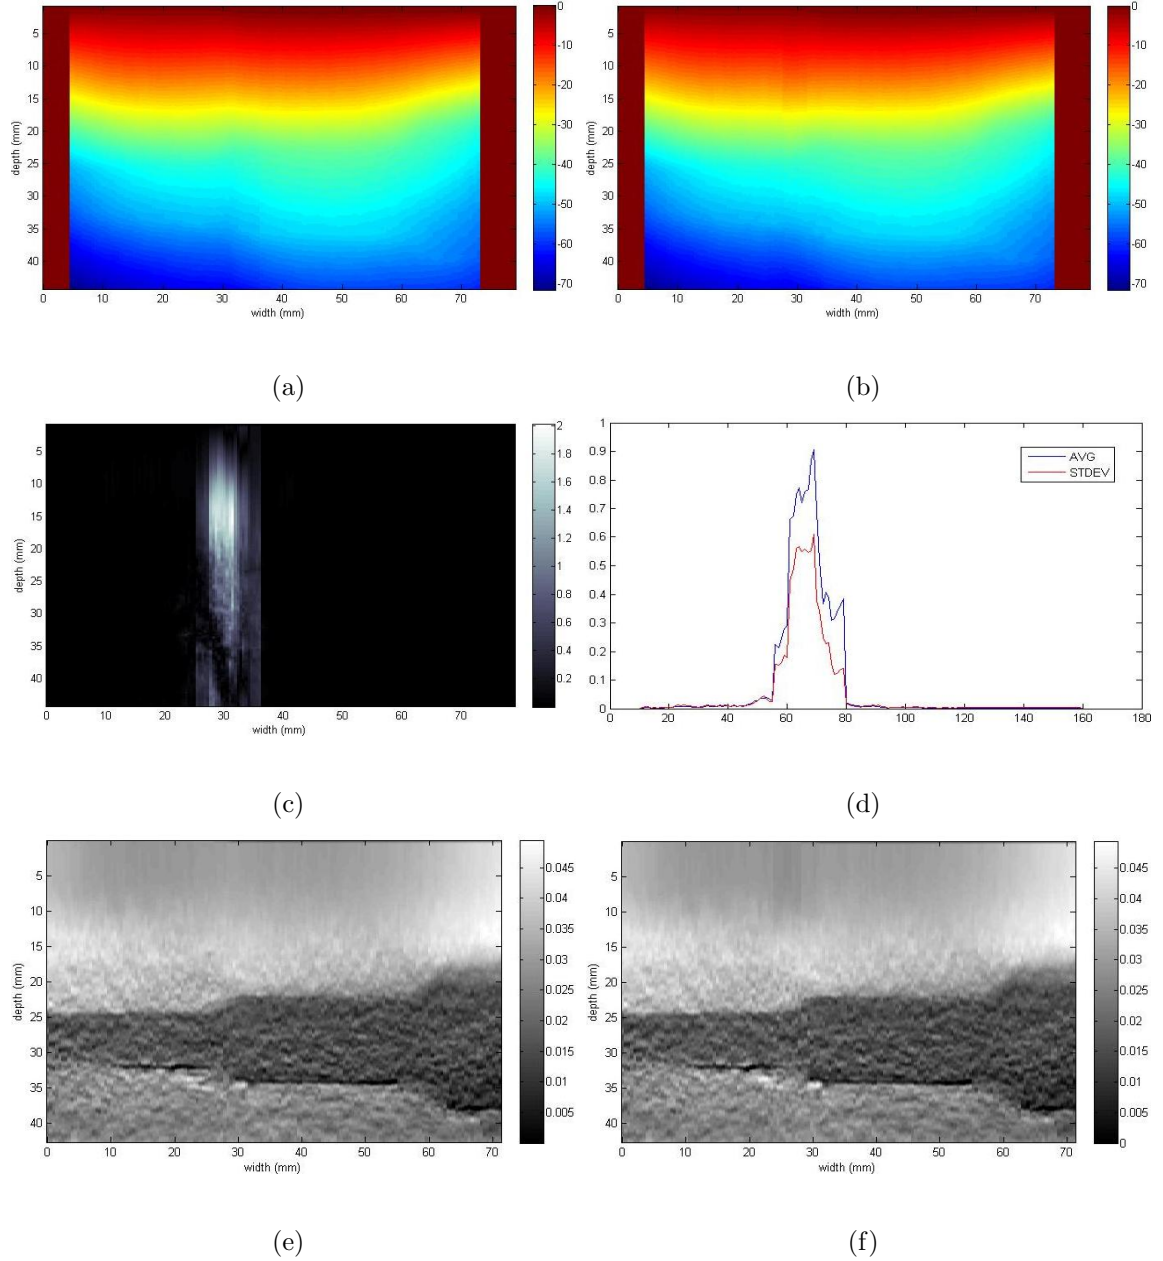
Panoramic displacement map of positions t_0 and t_3 (a), and of positions t_0 , t_1 , t_2 and t_3 (b), the absolute difference between them (c), and the mean and standard deviation of this difference, per line (d). The unit of displacement is pixels. Corresponding ultrasound elastography mosaics of positions t_0 and t_3 (e), and t_0 , t_1 , t_2 and t_3 (f).
